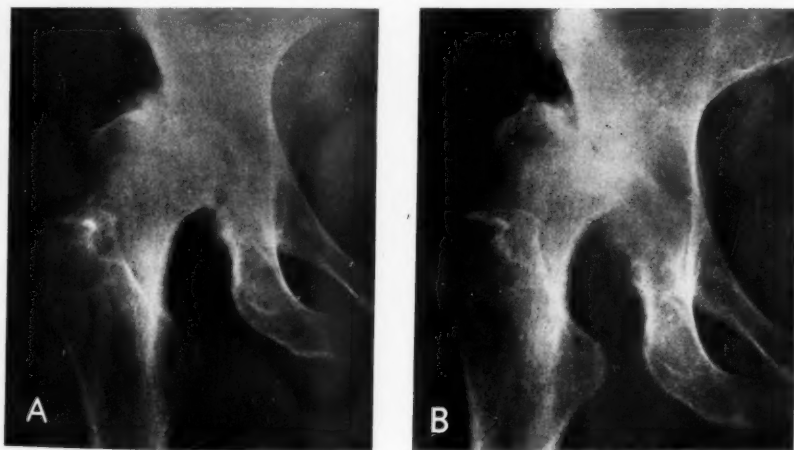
Case IV: Roentgenograms following oral steroid treatment for fifteen weeks. In addition to the severe destruction and subluxation of the right hip there was noticeable progression of the arthritic changes in the left hip, which was painless. A. May 1959. B. October 1959.
